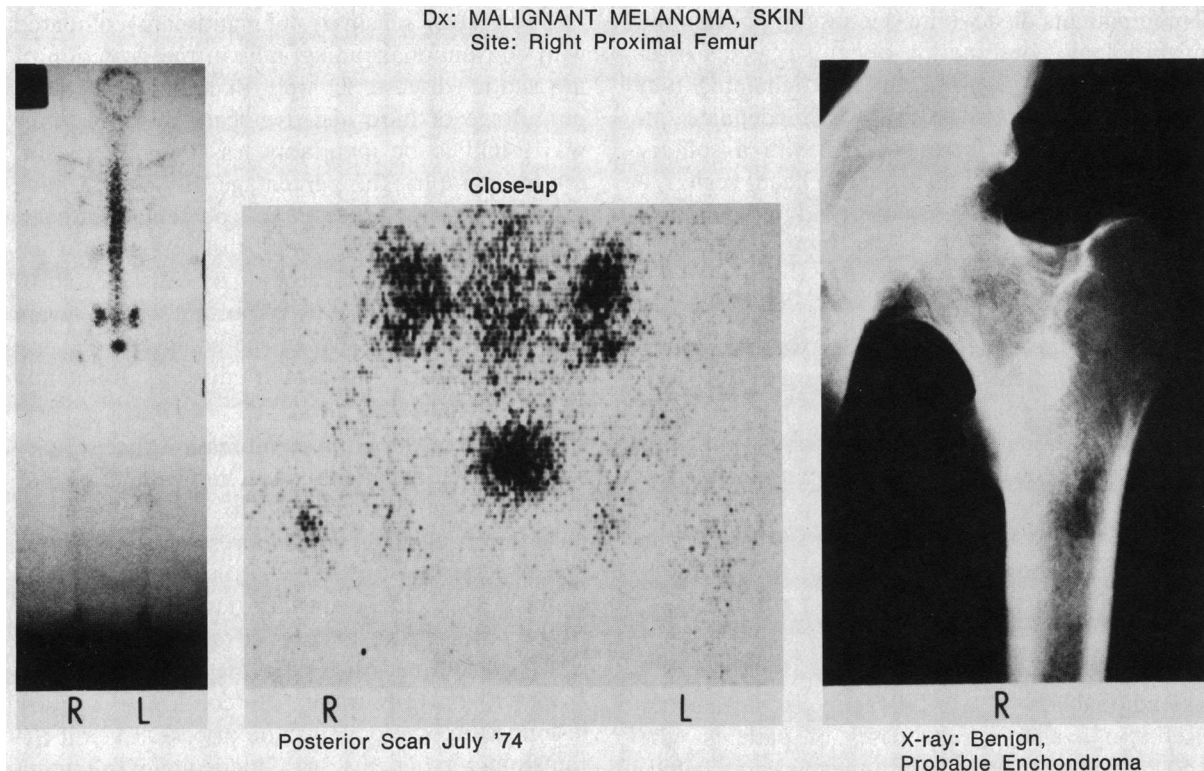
Bone scan of a 43-year-old man with malignant melanoma of the skin. A single focus of increased radioactivity is seen in the right proximal femur. The radiograph's appearance typified that of a benign lesion, probably an enchondroma.
